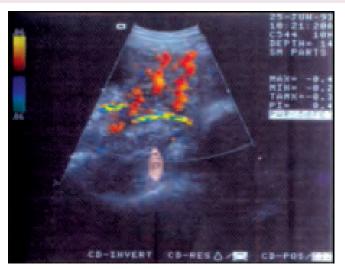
Uterine and arcuate arteries, visualized with color Doppler
